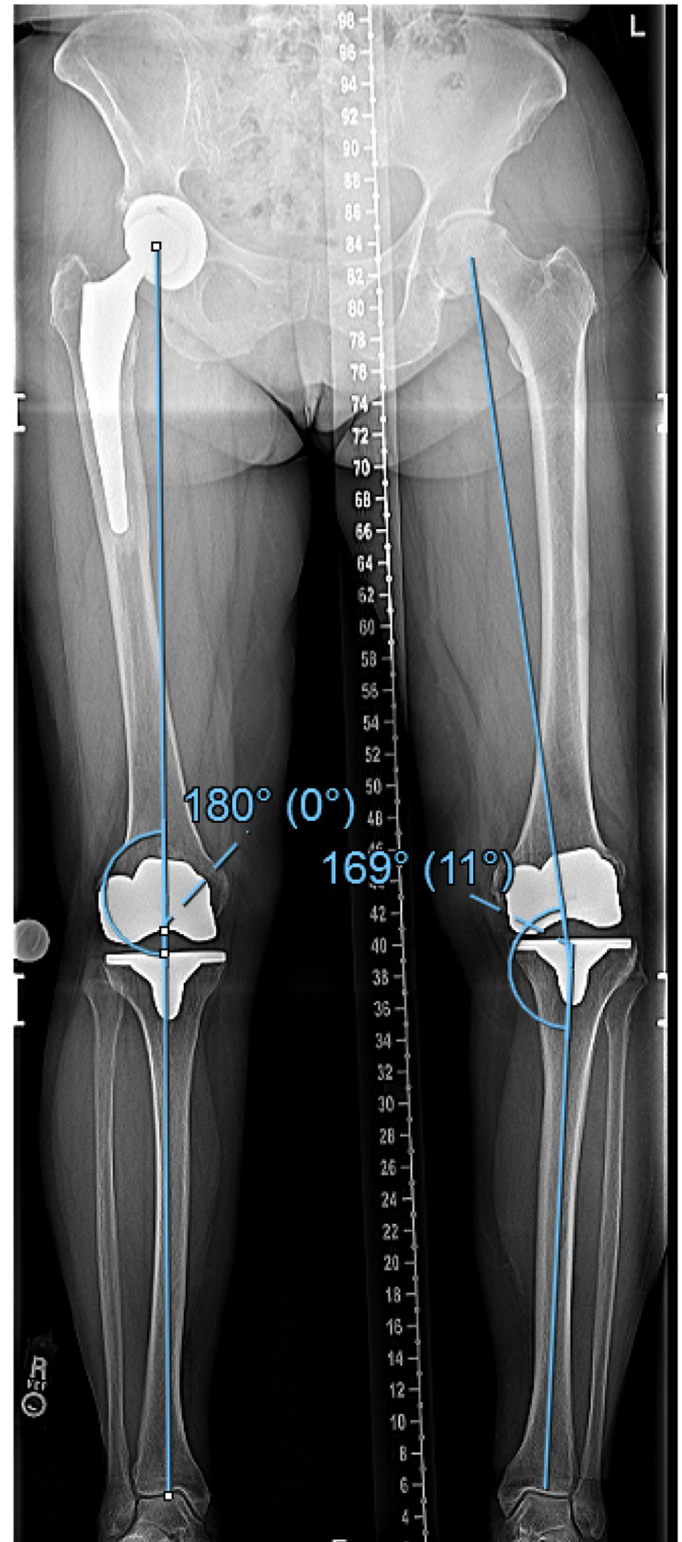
Postoperative radiographs in 2024, showing increasing lateral opening and varus deformity.
